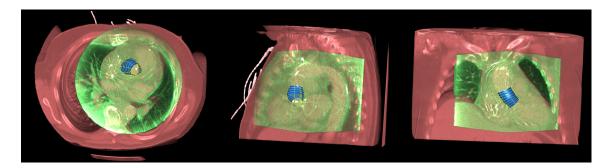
Example of the aligned pre-operative CT image I_1 (red channel) with the intraoperative 3D C-arm CT I_2 (green channel) and the mapped aortic valve model.
